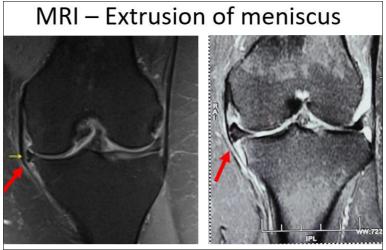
MRI - Ghost sign with extrusion of meniscus
